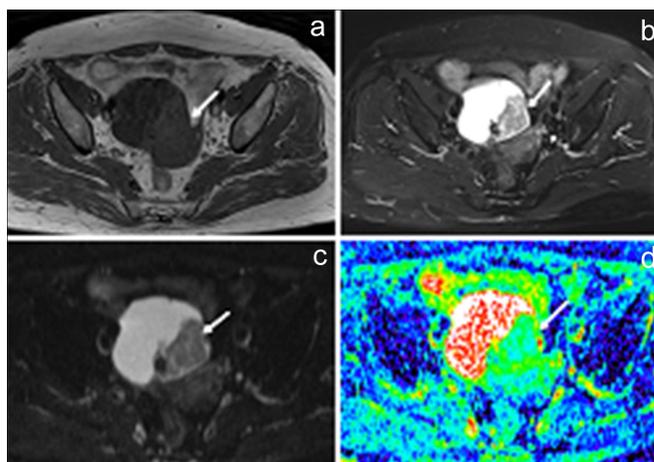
(a - d) Typical case 1: A female patient, 54 years old, ovarian serous cystadenocarcinoma. (a) Solid and cystic masses in the right appendage area, with equal signals (arrows) on the T1WI. (b) The T2WI fat suppression sequence showed solid and cystic lesions. (c) Solid lesions on the DWI were significant high signals. Cystic lesions on the DWI were equal signals and slightly higher mixed signals. (d) The ADC of solid lesions in the ROI was approximately $(1.15 \pm 0.14) \times 10^{-3} \text{ mm}^2/\text{s}$.
